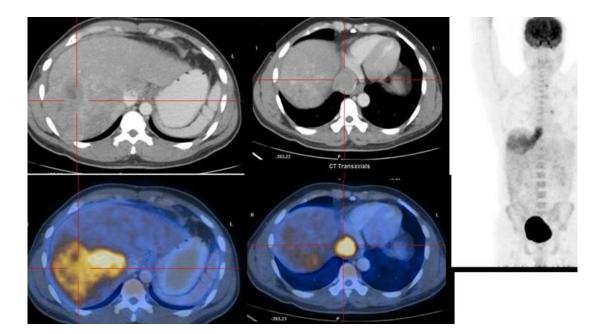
PET/CT images in a 45 year old male with HCC showing [¹⁸F]FDG avid right lobe primary HCC with IVC thrombus (Hepatitis Ag positive case). (Left) upper row: CECT liver transaxial, lower row: fused PET/CT transaxial image. (Middle) upper row: CECT and lower row: fused PET/CT transaxial image. (Right) MIP (Maximum intensity projection image) showing [¹⁸F]FDG distribution. Abnormal increased [¹⁸F]FDG uptake noted in large heterogeneously enhancing lesion (cross hair) involving right lobe of liver (9 x 10 cm) with necrotic component within it (SUVmax 7.0) and in filling defect in IVC ([¹⁸F]FDG avid tumour thrombus) extending up to right atrium (SUVmax 10.1) in middle image). No other [¹⁸F]FDG avid nodal or distant metastases.
